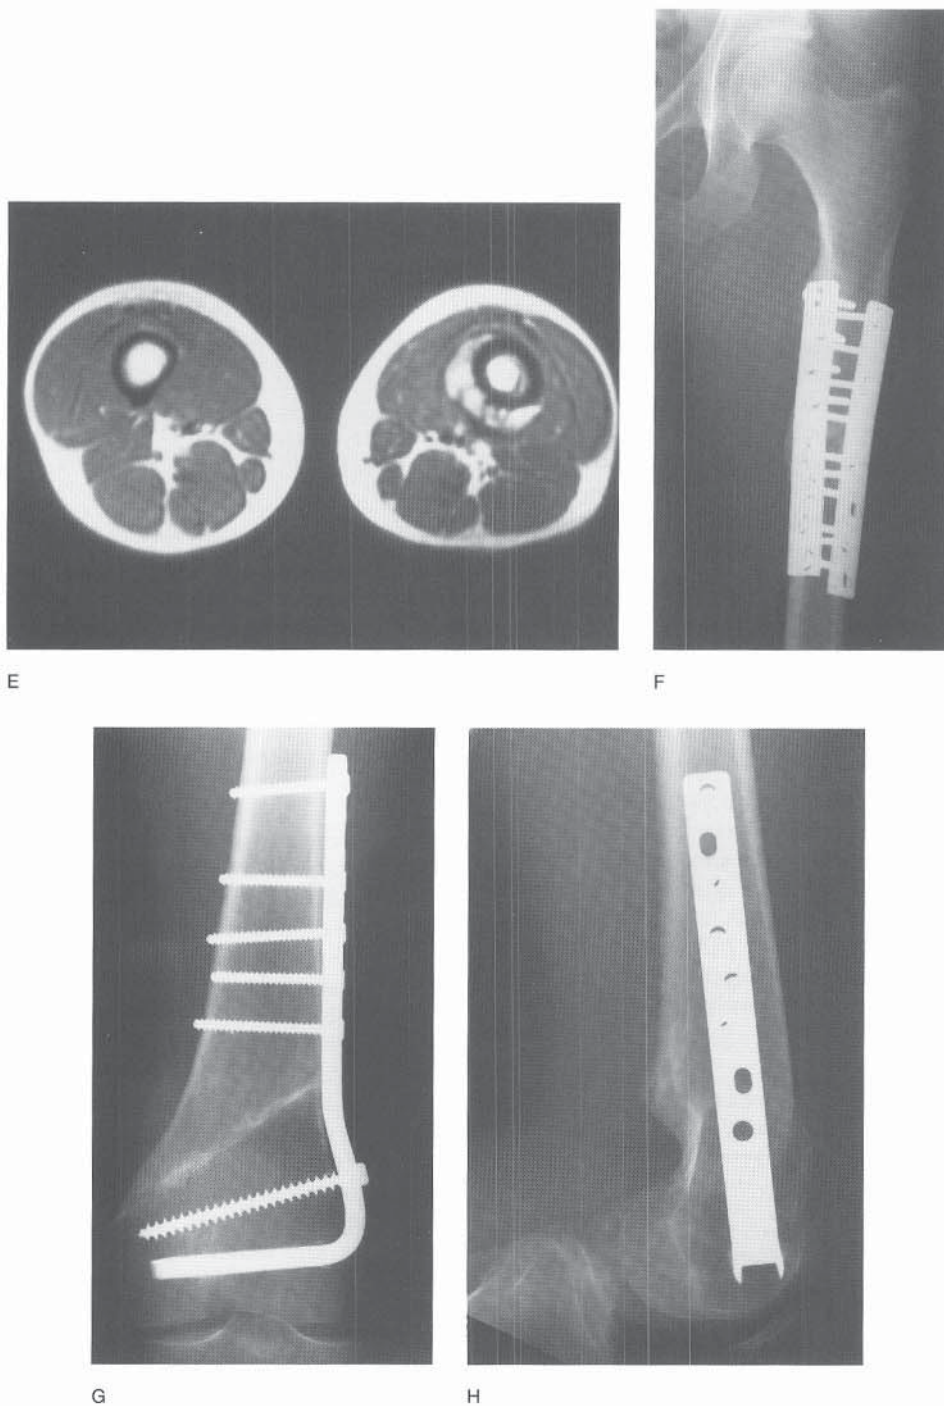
Continued.* E, Axial MR image obtained following induction chemotherapy. There has been considerable reduction in the extent and size of the soft tissue mass. After discussing the alternatives of radiation therapy and surgery for local control, the patient elected to undergo surgical resection. F to H, Radiographs showing the reconstruction. An intercalary resection with wide margins was performed and an allograft reconstruction was carried out. Both the hip and the knee joints were preserved. Both osteosyntheses healed, with very good function.
